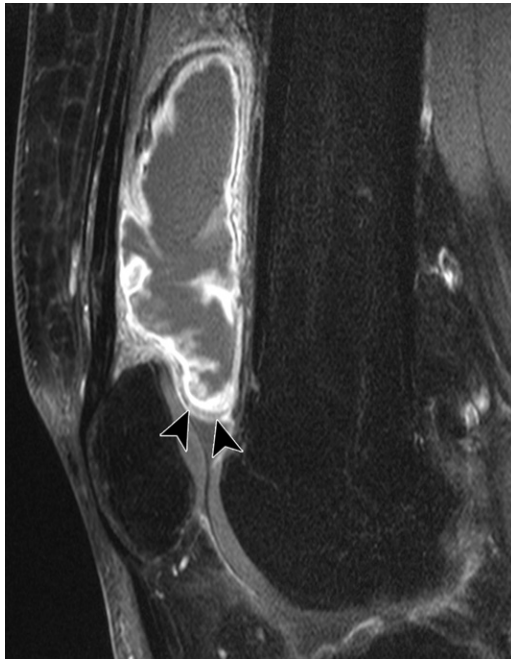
Complete suprapatellar plica in a 35-year-old man with a history of an intra-articular mass diagnosed at an outside hospital. Sagittal T1-weighted fat-suppressed MR image after intravenous injection of gadolinium contrast material shows a distended suprapatellar pouch with a thickened synovial wall related to an imperforate suprapatellar plica (arrowheads), which isolates the suprapatellar pouch from the remainder of the joint. There is no effusion in the remainder of the articulation. (Courtesy of Keir Fowler, MD, Fairbanks Memorial Hospital, Fairbanks, Alaska.)
